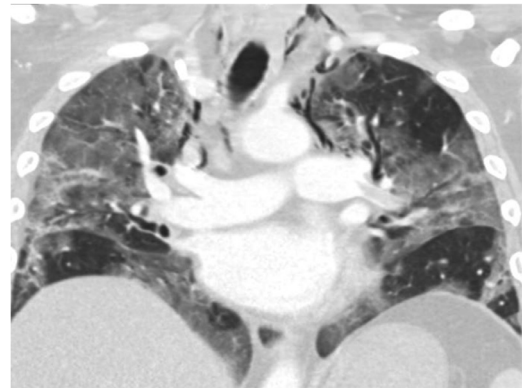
Computed tomography angiography (CTA) scan of the chest in coronal view revealing air that outlines multiple mediastinal structures including the aortic arch and extending to the lower neck.
